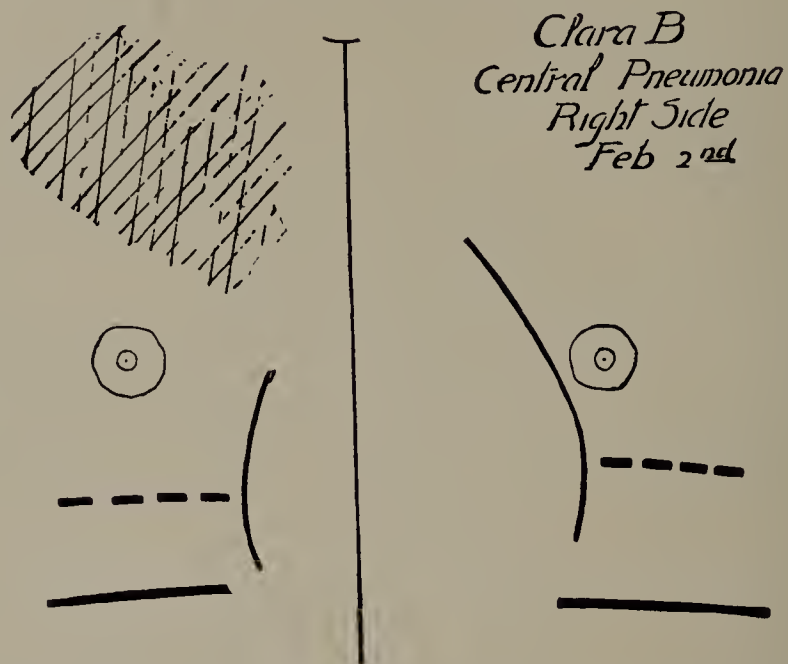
Clara B. February 2. First X-ray tracing. Central pneumonia of right side in girl eight years old. Shaded lung and shortened excursion of diaphragm on right side. (One-third life size.)
